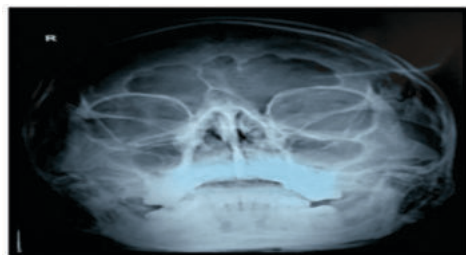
Immediate post-operative radiograph (PNS view)
